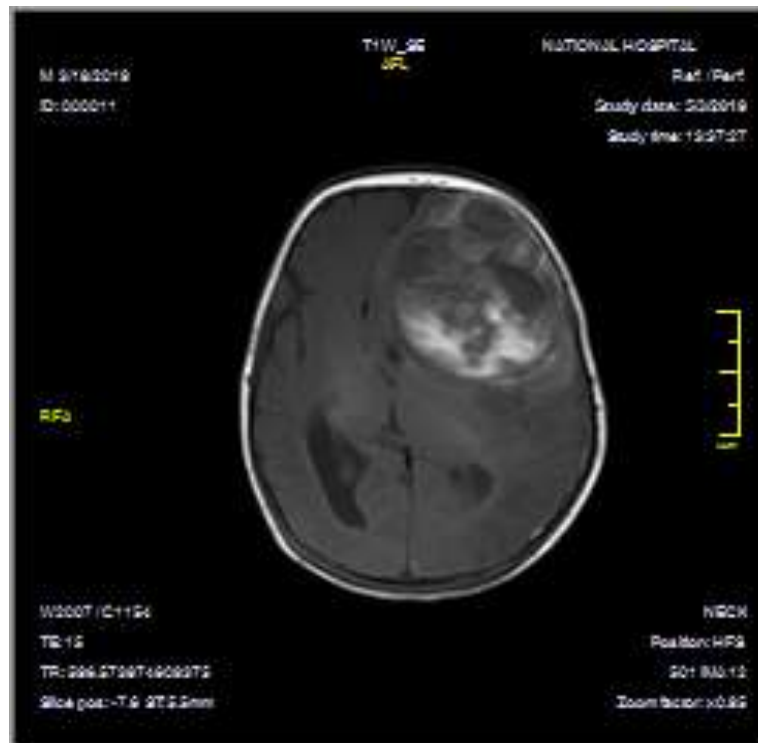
An axial T1 weighted magnetic resonance image of the brain at the level of the Sylvian fissures showing heterogenous intensity mass at the left frontal lobe with effacement of the ipsilateral Sylvian fissure and frontal horn of the lateral ventricle and associated severe subfalcine herniation.
